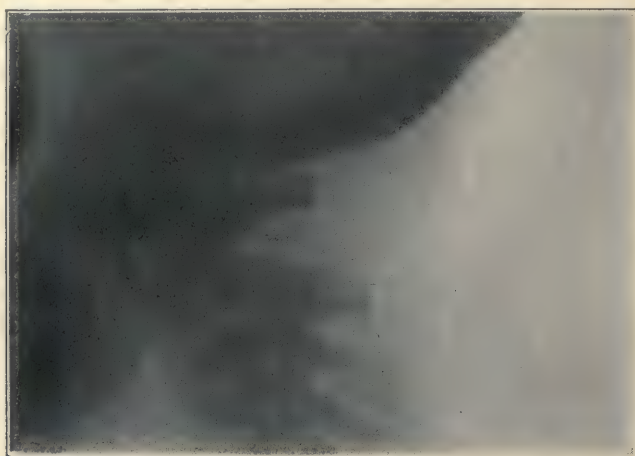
Unilateral Anterior Dislocation of Atlas in a Boy of Twelve Years, Showing Wide Angle between Laminae of Axis and Atlas. (Roentgen Department of Lane Hospital, San Francisco.)
